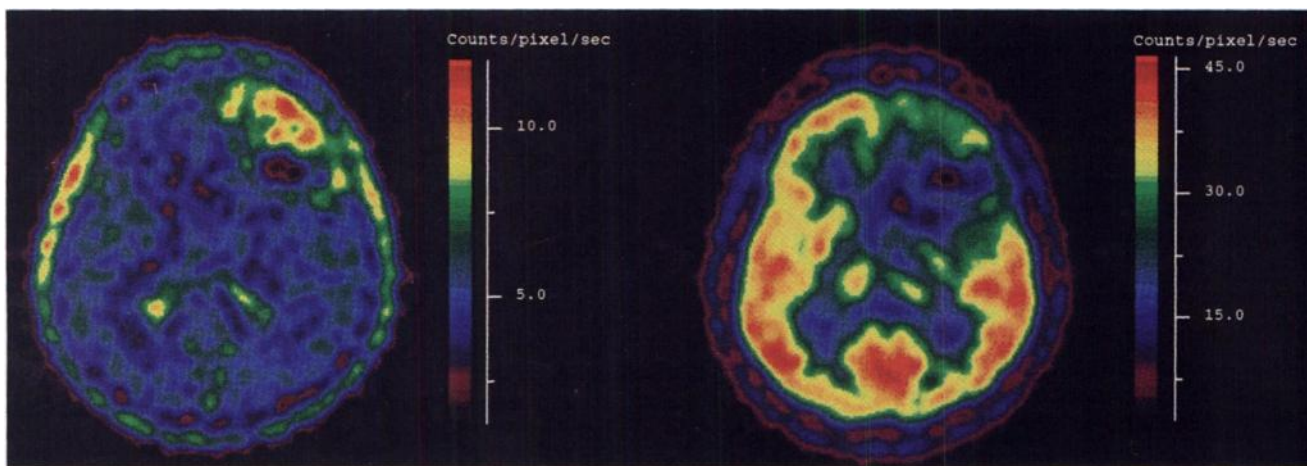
Patient with an untreated anaplastic astrocytoma, grade III (Patient 2). (A) MRI T2-weighted image shows two rim-shaped left frontal lesions with a mass effect and brain edema. (B) MRI T1-weighted image with gadolinium shows an intense BBB disruption. (C, left) On the 17.5-min image, intense accumulation of Tdr in the anterior part of the lesion, adjacent to a defect related to a necrotic area. Note the low and homogeneous uptake in normal brain structures and Tdr uptake over the choroid plexus and subcutaneous regions. (C, right) FDG-PET image shows a glucose metabolic rate intermediate between that of gray and white matter and a focus compared with that of the surrounding tissue.
